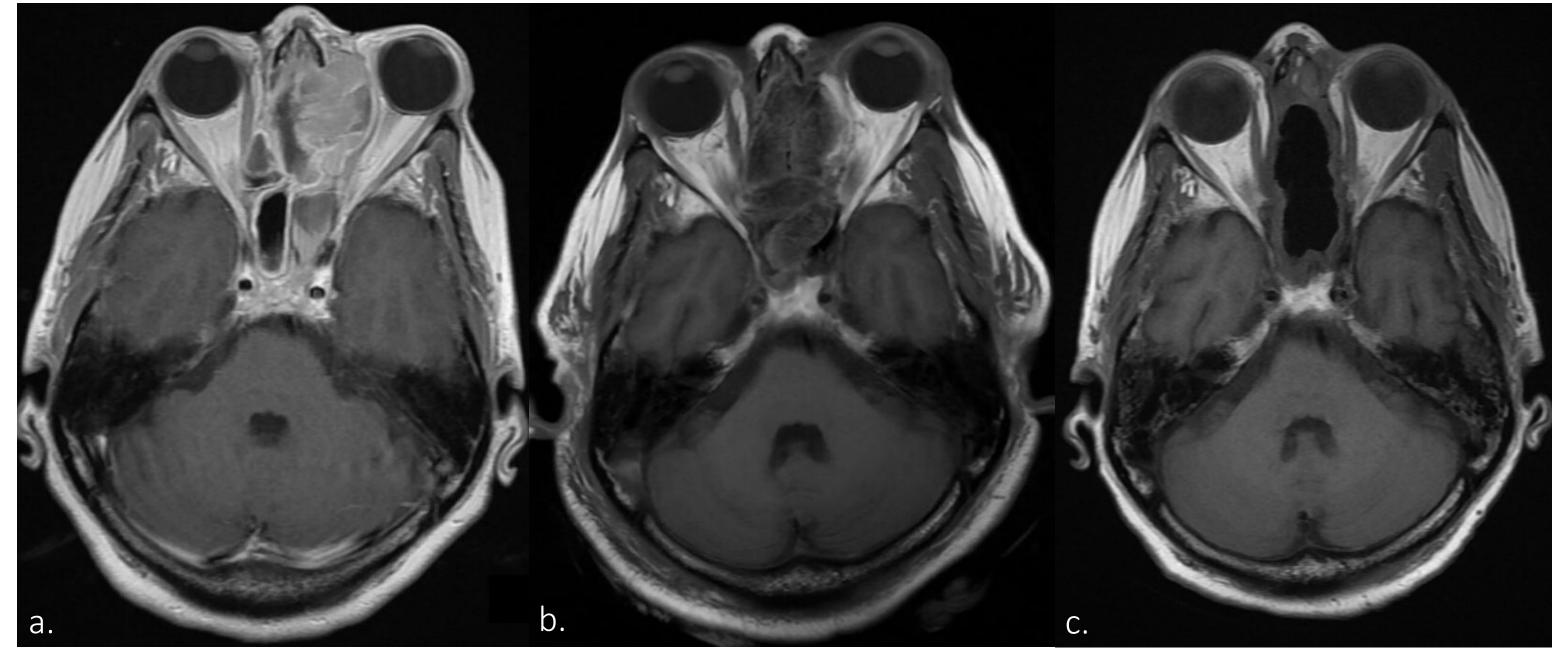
a. Pre-operative axial T1 MRI; b. Same day post-op coronal T1 MRI; c. Fivemonth post-op axial T1 MRI
